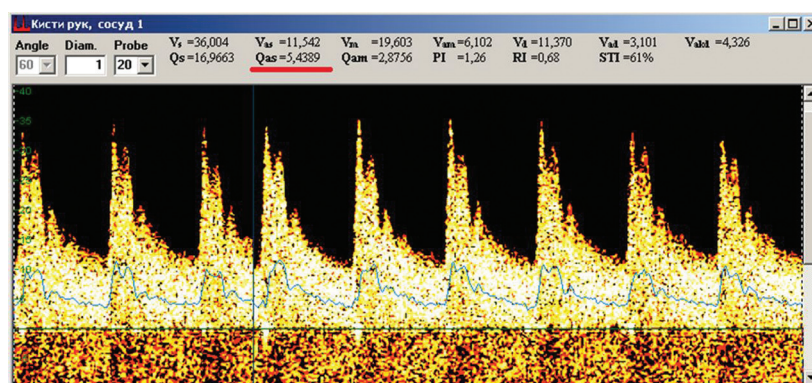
Doppler sonogram of Arcus palmaris superficialis of patient K., 68 years old; postoperative day 8
